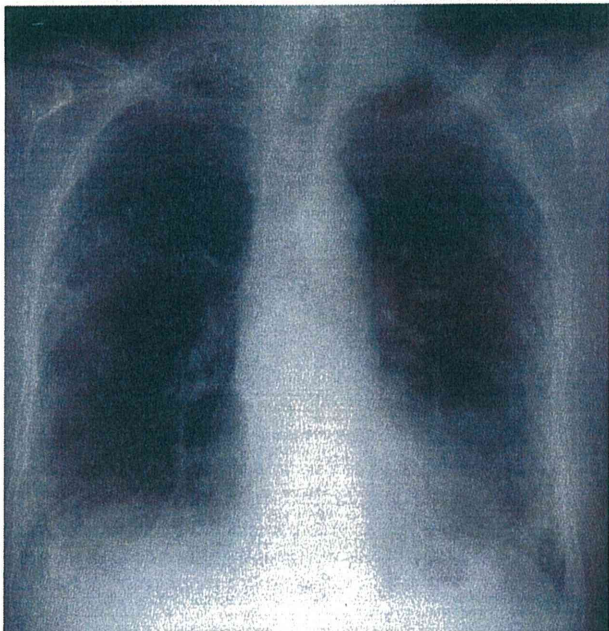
Chest X-ray of the patient in Case 3. Infliximab was discontinued due to interstitial pneumonia
